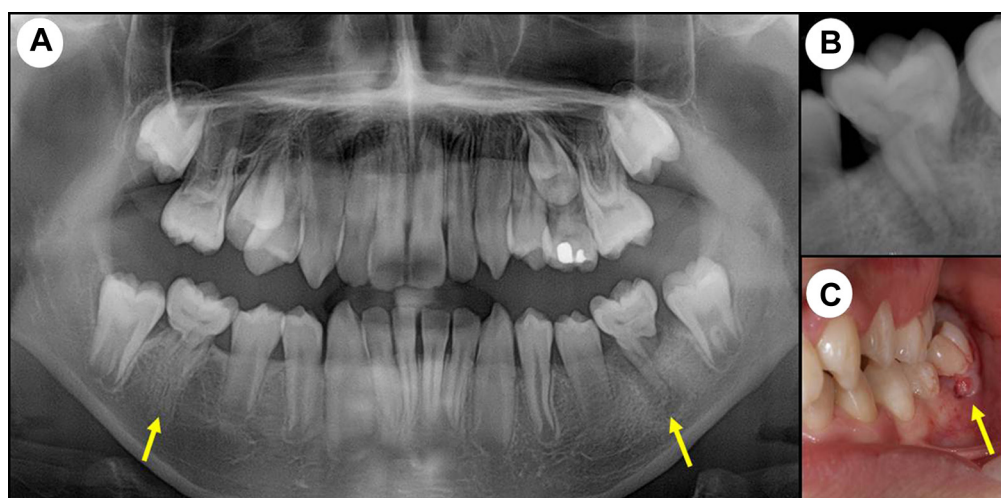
Case 4 (patient 4). Clinical photographs and radiographic films. A, Panoramic film of a boy (at 12 years and 6 months old) obtained 10 months after his first visit. Alveolar bone loss is visible at the furcation and apical areas of the lower left permanent molar. The roots of the upper and lower bilateral first permanent molars are thin and divergent, and the pulp cavity in the crown is constricted into a straight form (yellow arrow). B, Periapical film of the lower left permanent molar obtained 10 months after the first visit. Alveolar bone loss has reached the apex. C, Clinical intraoral photograph obtained 10 months after the first visit showing fistula formation on the buccal gingiva of the lower left permanent molar. The tooth had to be extracted because of tooth mobility, a positive reaction to percussion (+), and apical involvement.
